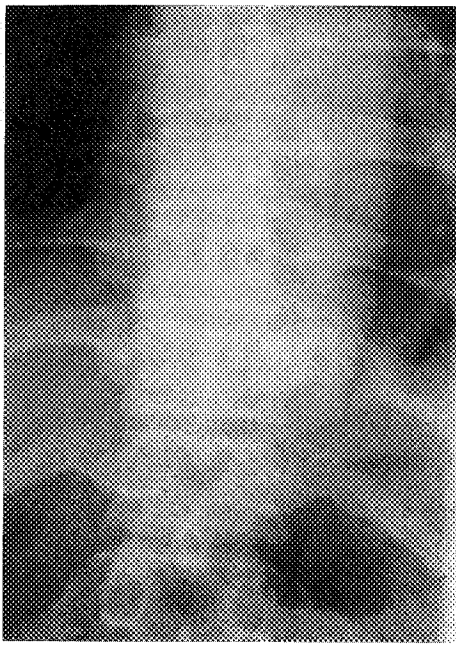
Plain radiograph of the thoracic spine after the operation, showing the incorporation of hydroxyapatite.
